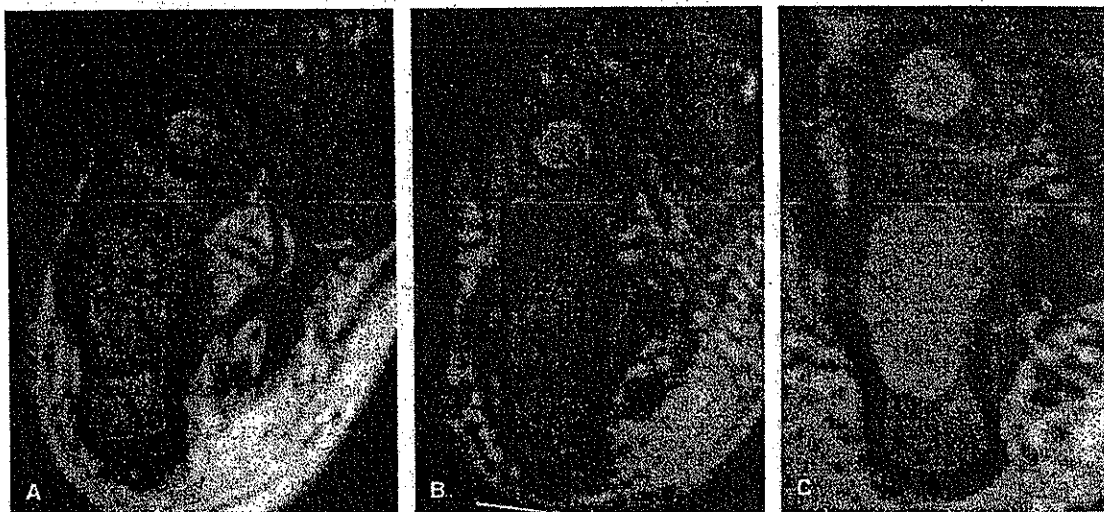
Patient 1. Sequential oblique axial magnetic resonance images perpendicular to the calcaneocuboid joint show the correction of the wedge-shaped distal calcaneus, the medially inclined calcaneocuboid articular surfaces, and the medial calcaneocuboid displacement from the first cast (A) to the third cast (B) to the fifth cast applied after percutaneous tenotomy (C). After application of the fifth cast, the calcaneocuboid joint was anatomically reduced and congruent.
